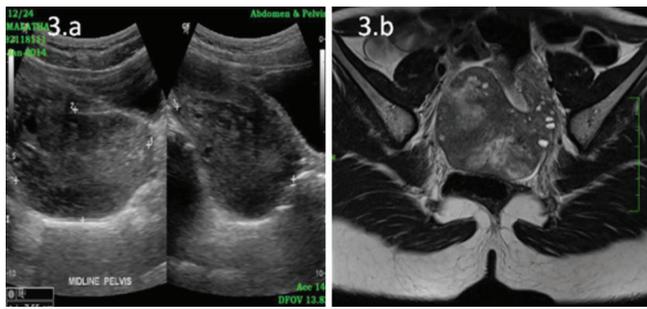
Ultrasound pelvis of a 17-year-old female shows a large well-defined heterogeneous lesion seen in the midline with communication with the left ovary (a). MRI pelvis of a 17-year-old female shows an enlarged left ovary which shows peripherally placed follicles with hematoma in the center (b).
